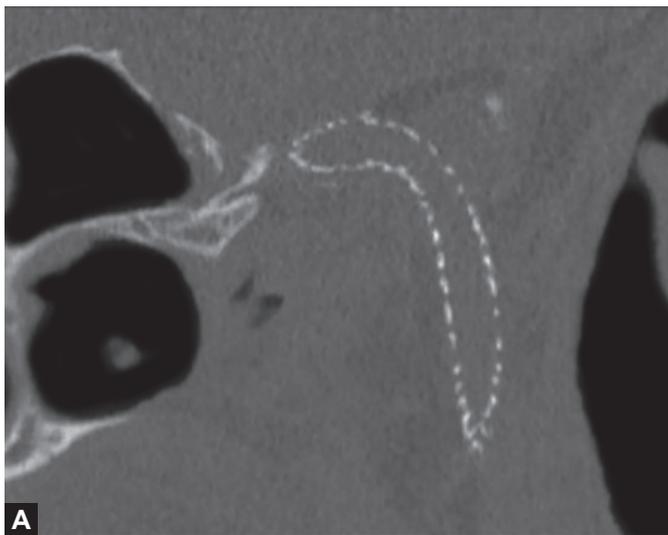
(A) The portion of the petrous apex medial to the internal carotid artery is involved by the tumor. Therefore, this tumor is classified as the Fisch class C3. (B) Note the vertical portion of the internal carotid artery completely encased by the tumor. (C) Postoperative T1 enhanced image, F: fat. (D) The magnetic resonance imaging (MRI), fat suppression axial view shows no residual tumor, (F: Fat).
